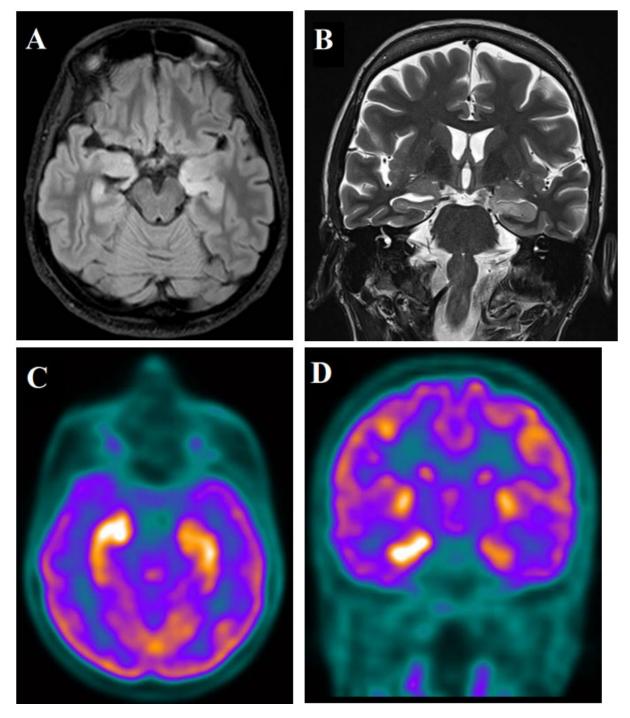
Neuroimaging findings for case 2. Axial FLAIR and coronal T2-weighted sequences on magnetic resonance imaging demonstrating signal hyperintensity in the medial temporal lobes (A, B). Hypermetabolism is demonstrated in the medial temporal lobes on fluorodeoxyglucose positron emission tomography (C, D).
